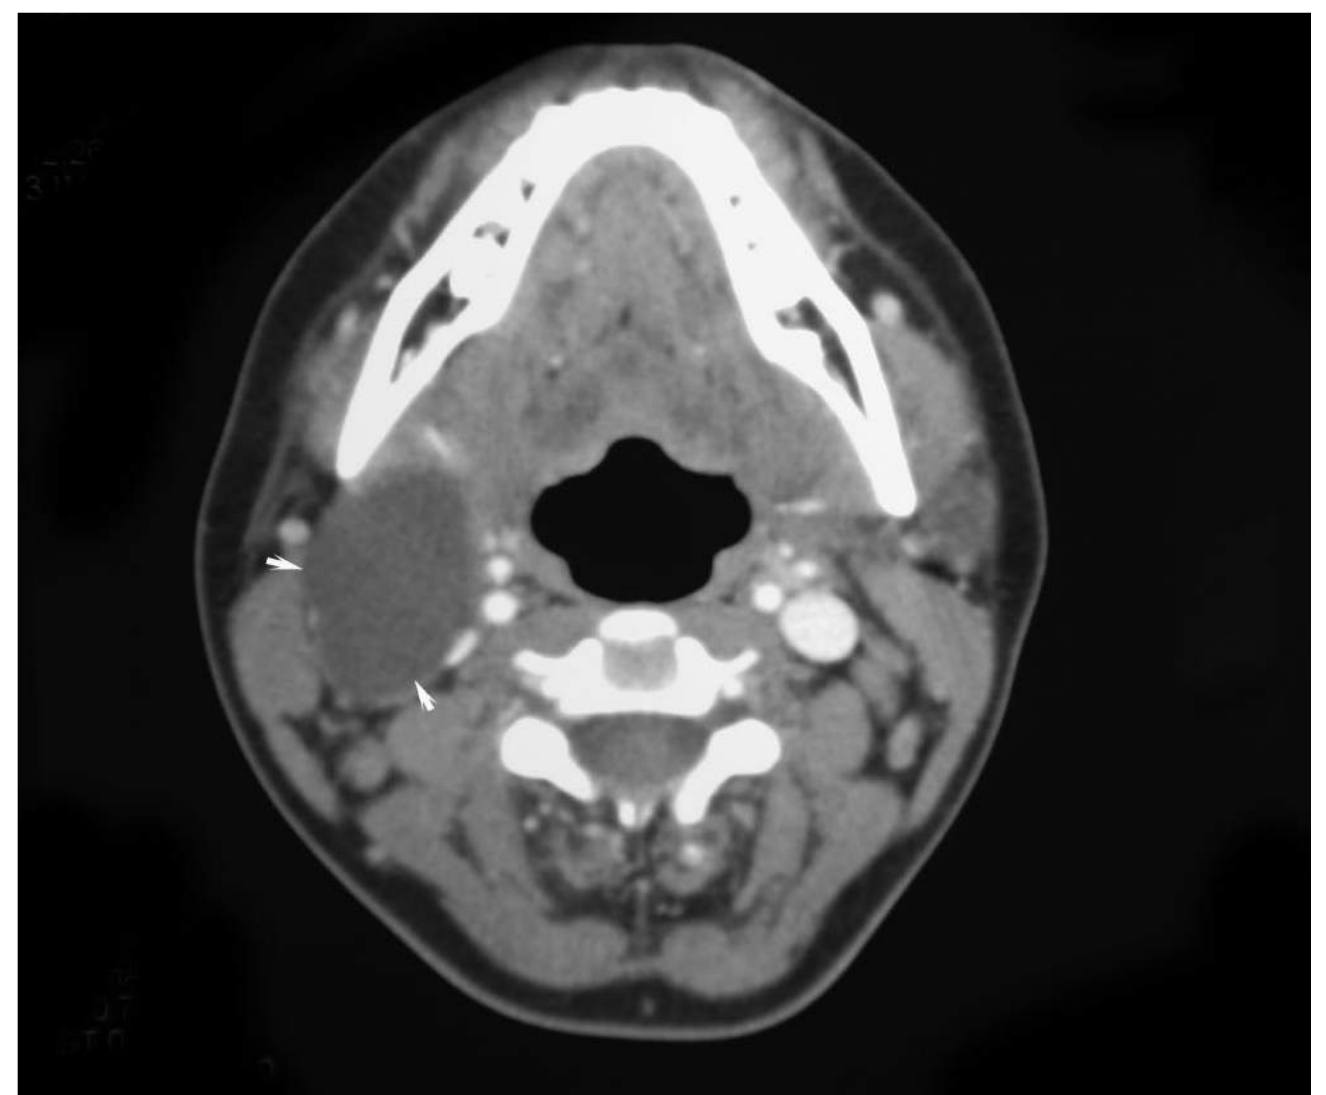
■ Second Branchial Cleft Cyst. Neck CT showing second branchial cleft cyst. (Photo contributor: Scott Manning, MD.)
